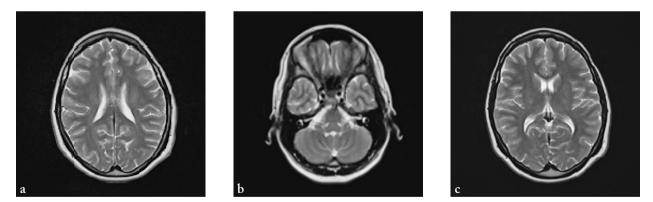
(a-c) Normal MRI of the brain six weeks after first clinical presentation.
